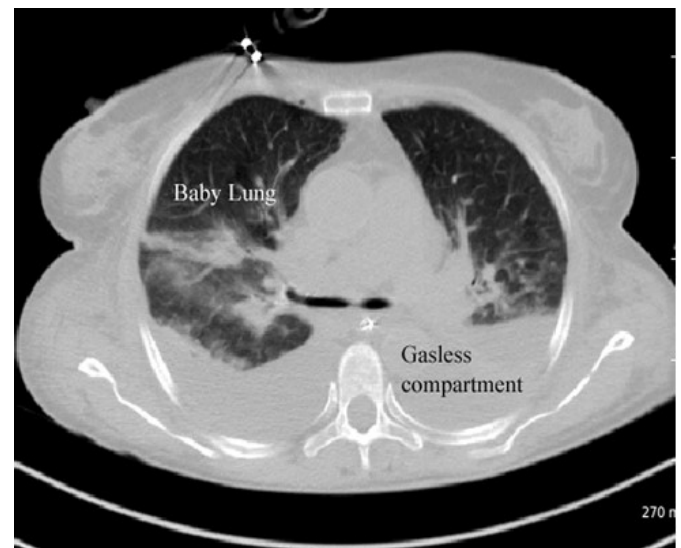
A CT scan of a patient with ARDS and injured lungs in the dependent lung regions leaving only ventilated in the non-dependent part of the lung
